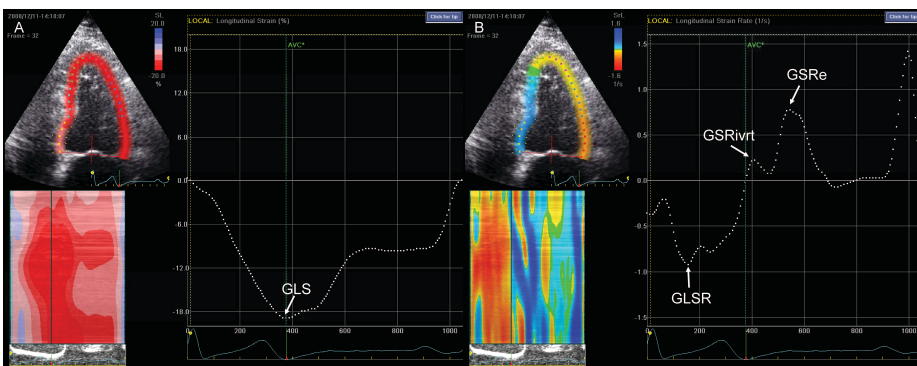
Global longitudinal strain and strain rate curves. Global longitudinal strain (panel A) and strain rate (panel B) curves obtained by speckle-tracking analysis from an apical 4-chamber view.
